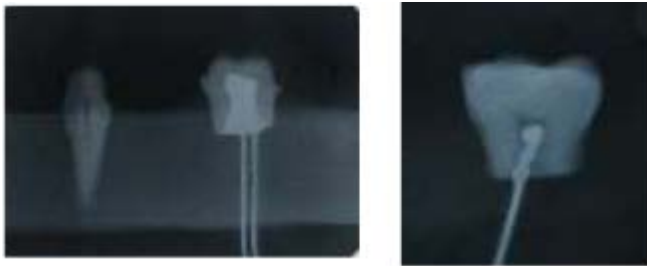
Radiographic confirmation of thermocouple molar.
